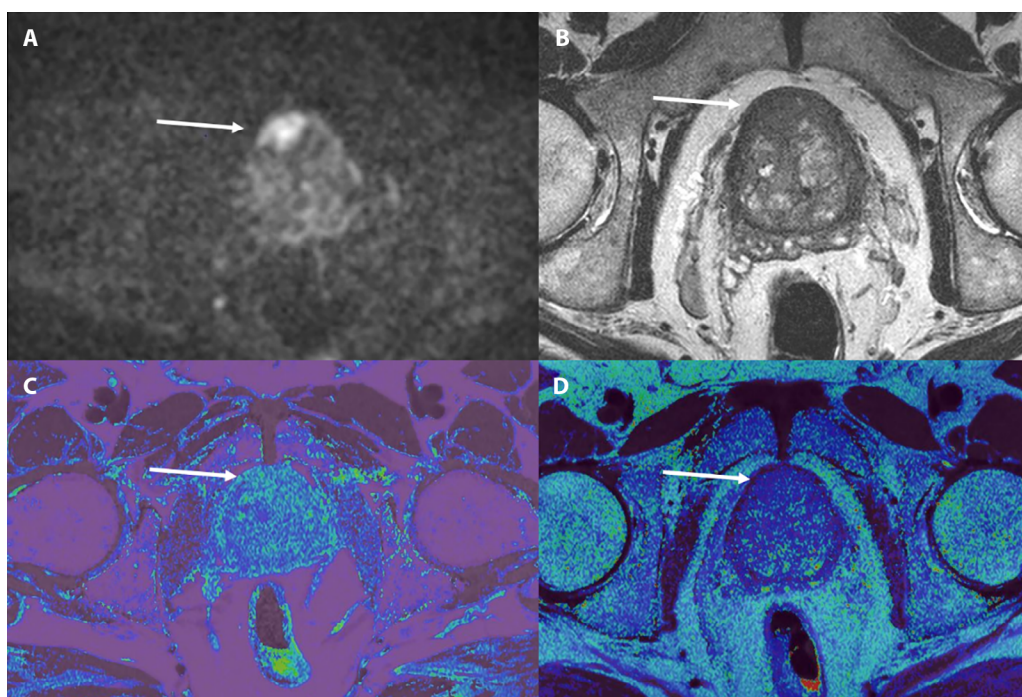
Example of a patient with a lesion in the right part of the central zone. A diffusion restriction (A, DWI, B 1600) and a hypointense T2 signal with blurred margins is seen (B), corresponding to a PIRADS vs 5. These lesions are not clearly visualized in the T1 (C), and T2 (D) maps. However, ROIs drawn in the lesion on the DWI and copied and pasted in the same position on the maps showed a different T1 of the lesion (1350 ms) vs the normal transition zone contralateral and a different T2 of the lesion (80 ms) vs the normal transition zone contralateral (128 ms).
